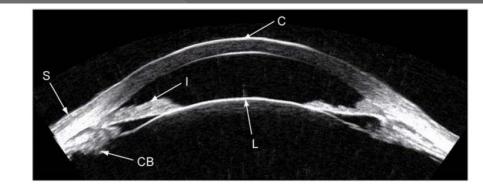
High resolution ultrasound image of the anterior segment of the eye obtained with arc-scan geometry. Visualised structures include the cornea (C), sclera (S), iris (I), anterior lens surface (L) and ciliary body (CB). (Image reproduced courtesy of Dr R H Silverman, Department of Ophthalmology, Weill Medical College of Cornell University, New York)
